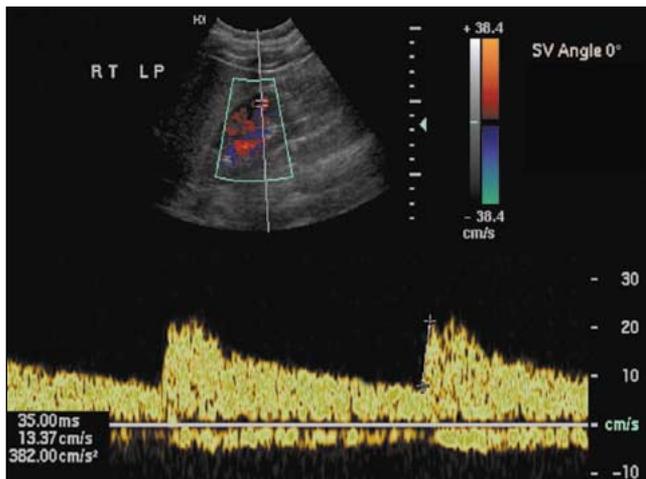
A, Normal intraparenchymal waveforms show a rapid systolic rise and a well-defined ESP. The acceleration time and index are both normal. B, This image from another patient without RA stenosis shows a more confusing waveform. There is no well-defined ESP, but the initial portion of the systolic rise is normal. Doppler indices should be taken from the initial portion of the waveform, not the highest point of the velocity spectrum.
